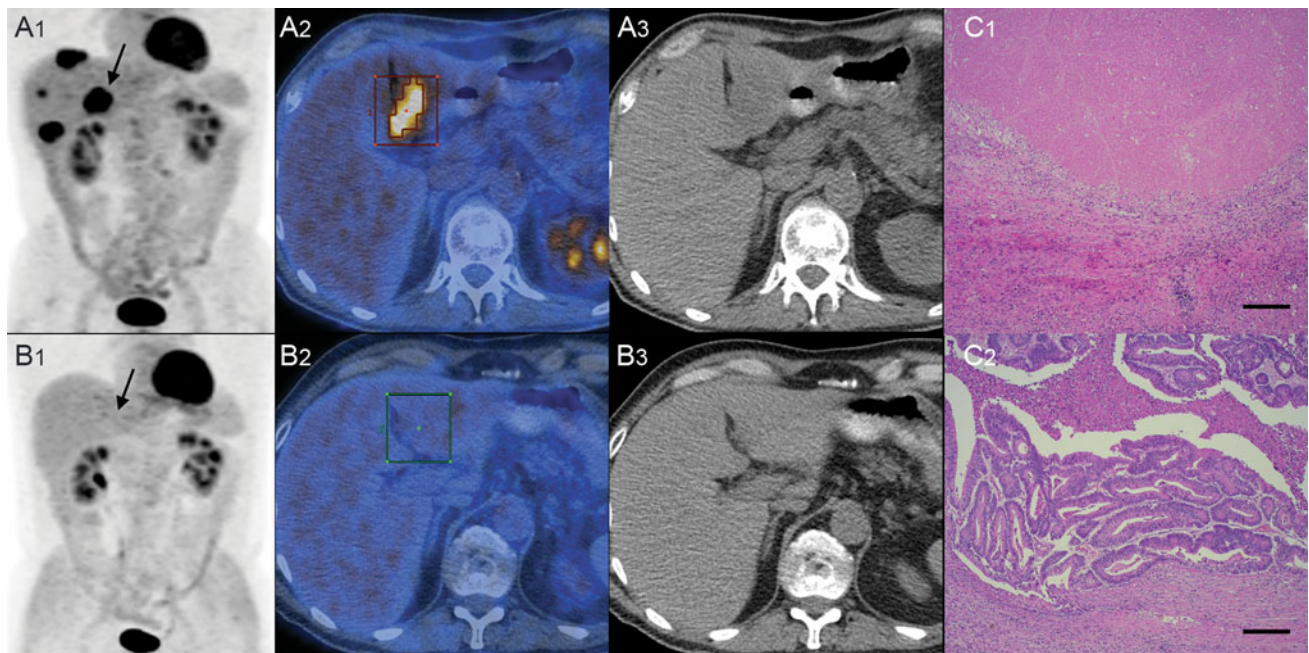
55-year-old man with hepatic metastases of colon carcinoma pT3 N2 M1. a_{1–3} Initial PET/CT (7 August 2009) with five FDG active liver metastases—the lesion in segment III (arrow) was further analysed. b_{1–3} After 6 cycles of FOLFOX with Avastin (until 6 October 2009) the SUV uptake decreased significantly (dSUV
